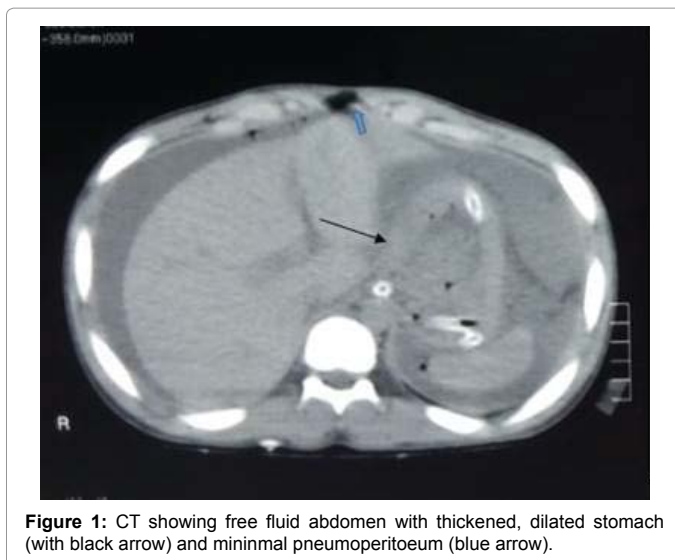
CT showing free fluid abdomen with thickened, dilated stomach (with black arrow) and minimal pneumoperitoneum (blue arrow).
